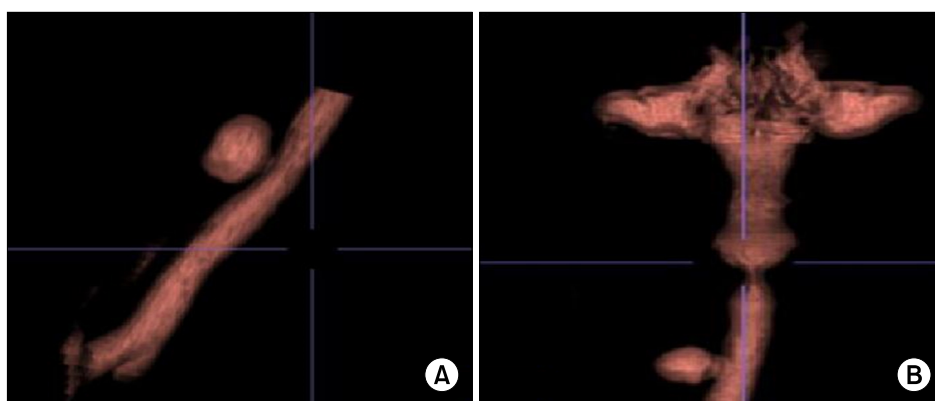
(A, B) Three-dimensional reconstruction from the initial preoperative computed tomography scan showing the tracheal diverticulum with a communication tract.
